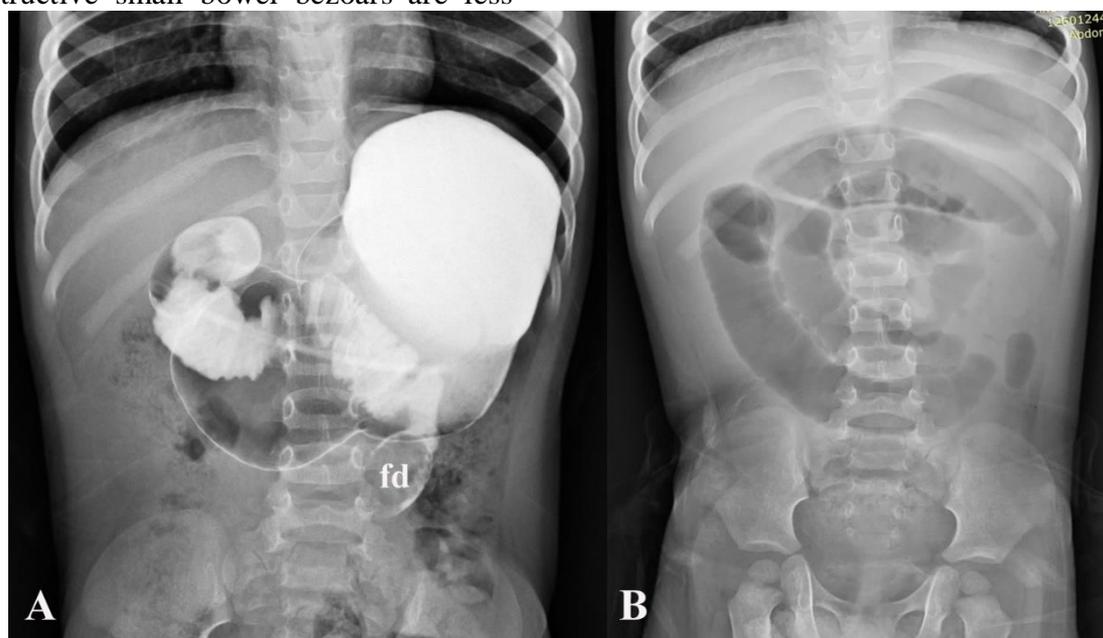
A) Upper gastrointestinal series shows an intraluminal filling defect (fd) in the proximal small bowel consistent with bezoar. B) Abdominal radiograph AP view shows sausage shape dilatation of small bowel and distal migration of obstruction.
